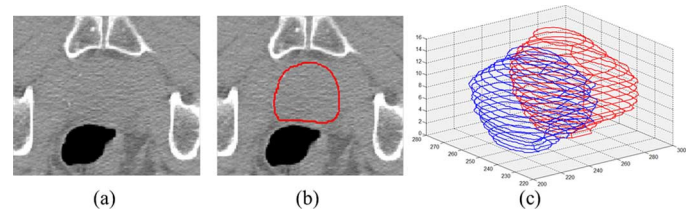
(a) Image slice of a 3-D prostate CT image. (b) Manual segmentation of the prostate in this slice. (c) Manual segmentations of prostates from two treatment images of the same patient.
